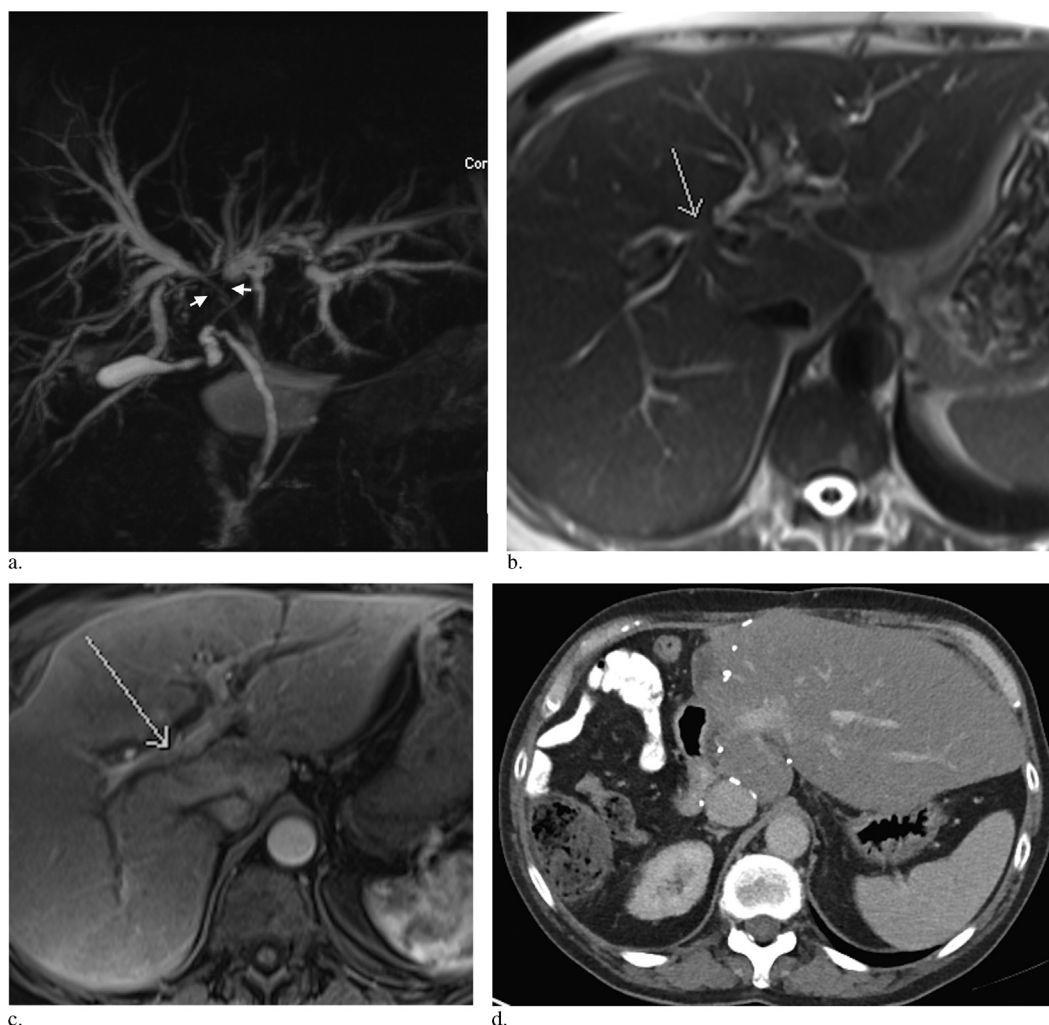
Images from a 60-year-old woman presenting with jaundice. (a) Coronal T2-weighted MR image demonstrates an ill-defined stricture at the level of the hilum (arrows) and intrahepatic bile duct dilation. (b) Axial T2-weighted image confirming the lesion infiltrating the biliary confluence as well as the right main biliary duct (arrow). (c) Postcontrast T1-weighted fat-saturated image shows the tumor infiltrating the periportal space, abutting—but not invading—the right PV (arrow), and clear of the main PV. The appearances are consistent with a Bismuth–Corlette type II tumor. There is no evidence of local lymphadenopathy or metastatic disease, for a classification of stage II disease (T2N0M0) according to Jarnagin–Blumgart and AJCC classification, amenable to surgical resection. No cholangitis or other indications for preoperative biliary drainage were present. Therefore, an extended right hemihepatectomy was performed. (d) There was no evidence of recurrence on CT at 2 years after resection.
